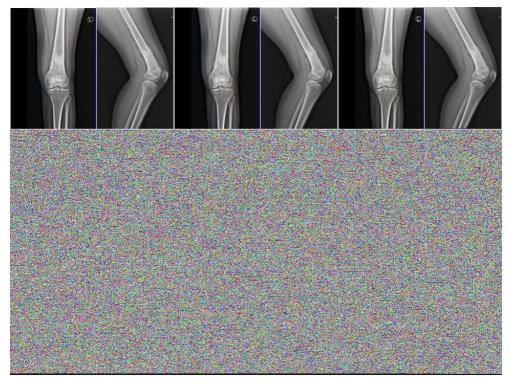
Plain radiograph (AP and lateral views) showing a sclerotic, destructive lesion in the lower end of femur with abnormal periosteal reaction.
